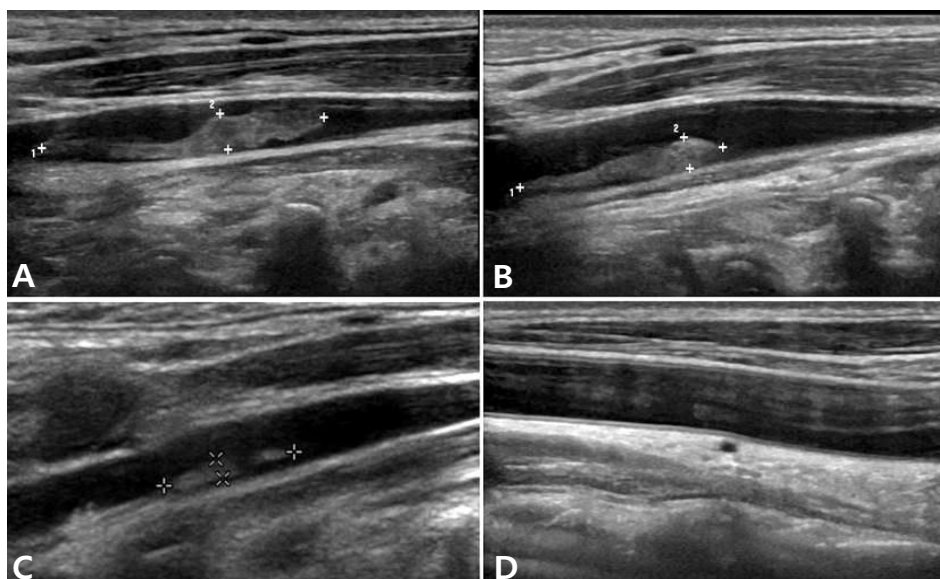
Shrinkage of thrombosis in the right jugular vein after parenteral antibiotics therapy. (A) A 3.0×0.36 cm elongated solid mass was observed. (B) Intraluminal thrombus was measured approximately 2.21×0.32 cm. (C) Intraluminal thrombus was measured approximately 1.03×0.16 cm. (D) Follow up ultrasonography was done on sixth day after discharge. The resolution of thrombus was confirmed.
